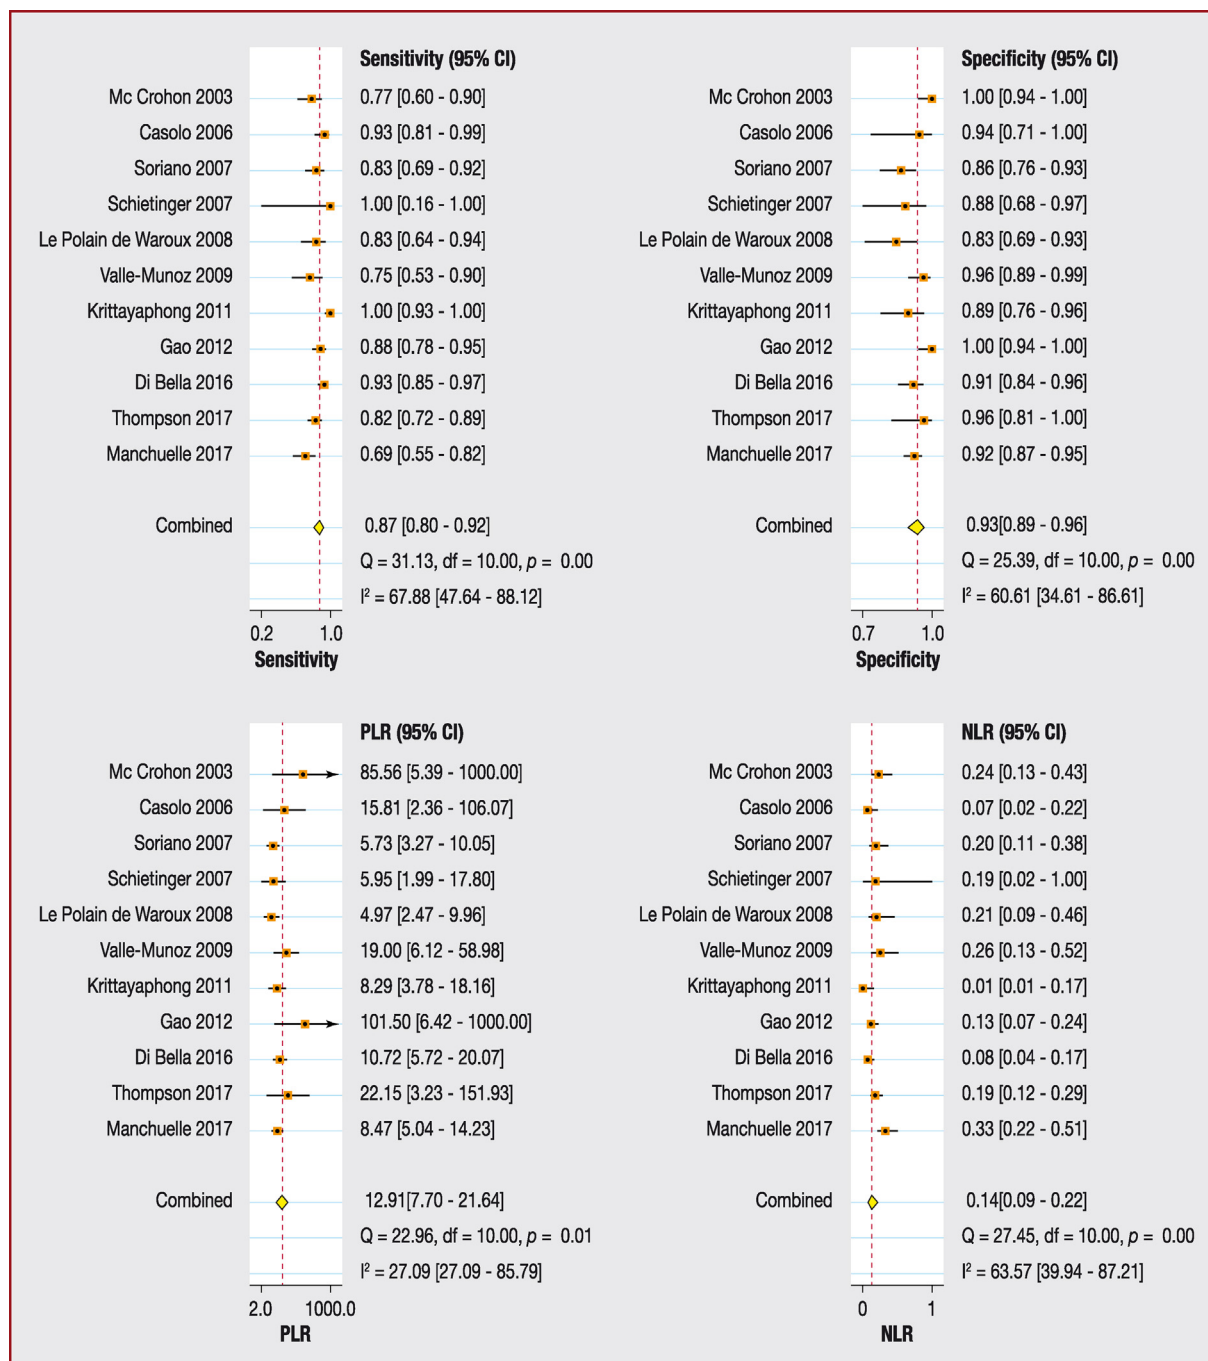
Diagnostic accuracy of the presence of subendocardial or transmural late gadolinium enhancement on cardiac magnetic resonance imaging to detect coronary artery disease. CI: confidence interval; NLR: negative likelihood ratio; PLR: positive likelihood ratio.
